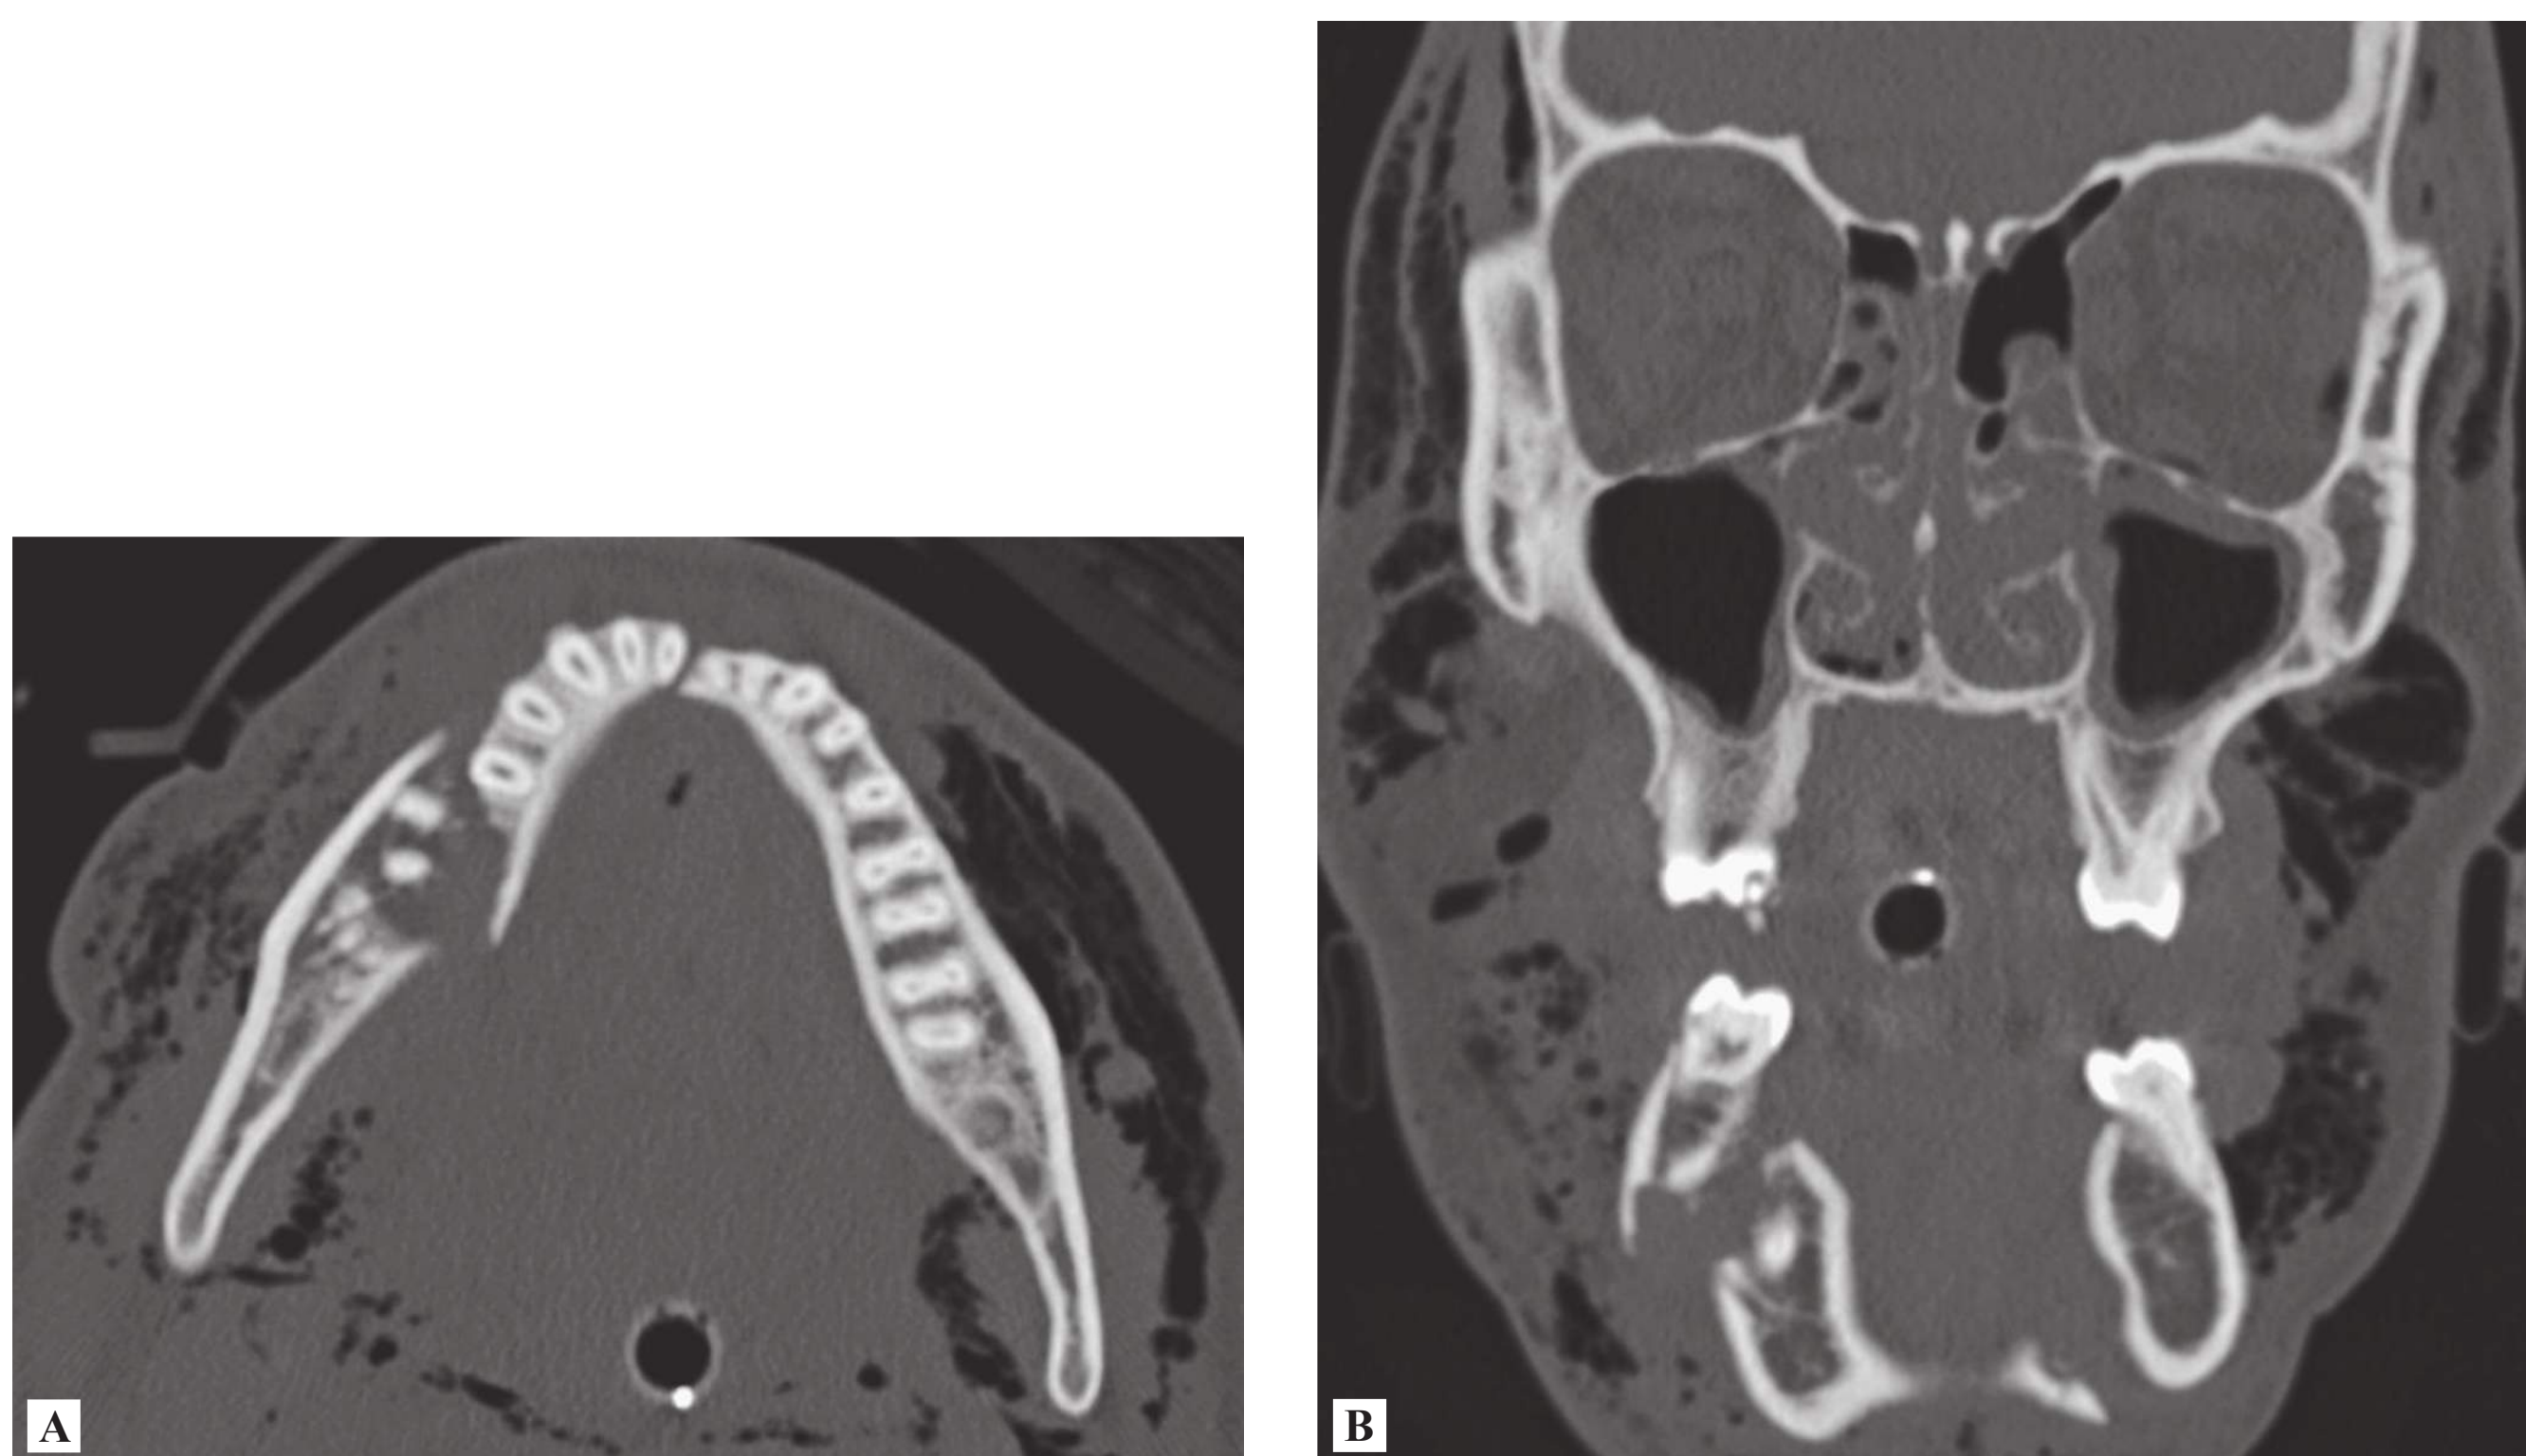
■ Mandibular Fractures. Axial (A) and coronal (B) views of a maxillofacial CT reveal a right mandibular body and a parasymphyseal fracture. (Reproduced with permission from Block J, Jordanov MI, Stack, LB, and Thurman RJ (eds). *The Atlas of Emergency Radiology*. New York: McGraw-Hill; 2013; Fig. 1-99A and B.)
